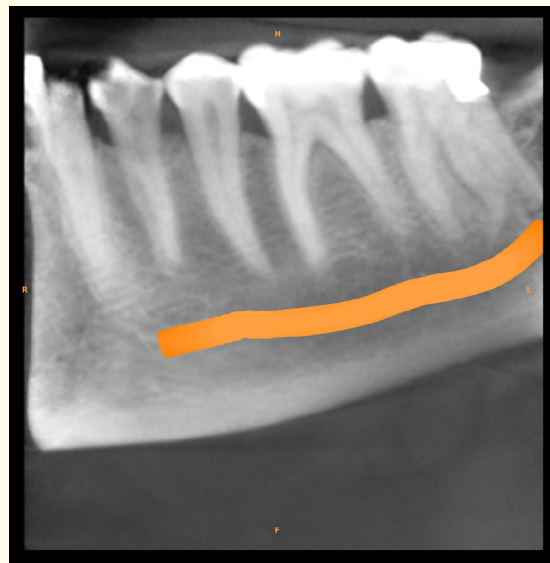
Sagittal CBCT slice shows the presence radix entomolaris.
